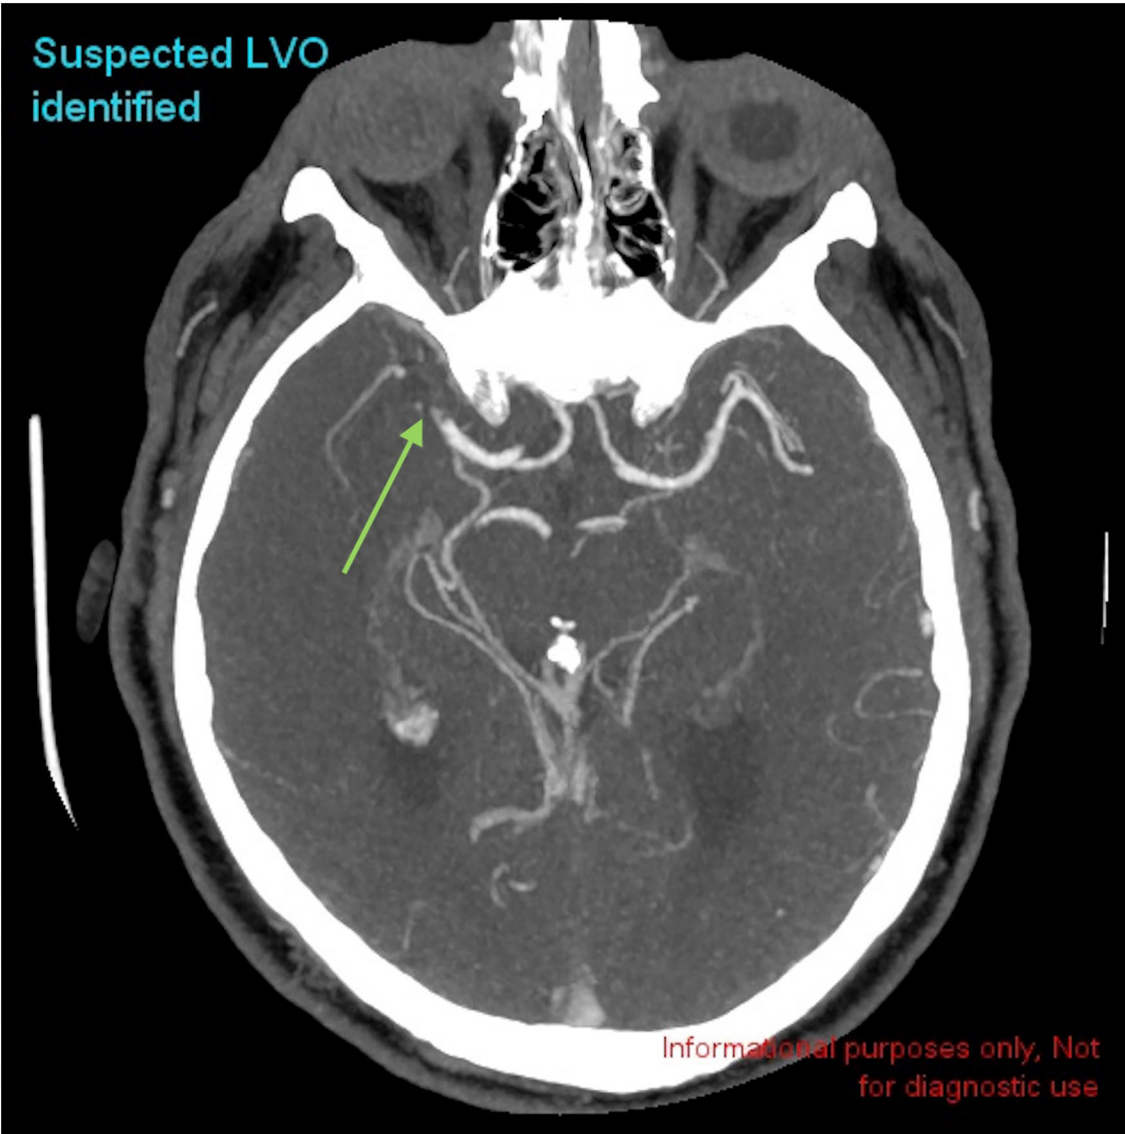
Example of a positive LVO identified by CINA®. There is a large vessel occlusion in the distal right MCA-M1 branch on CTA (green arrow).
